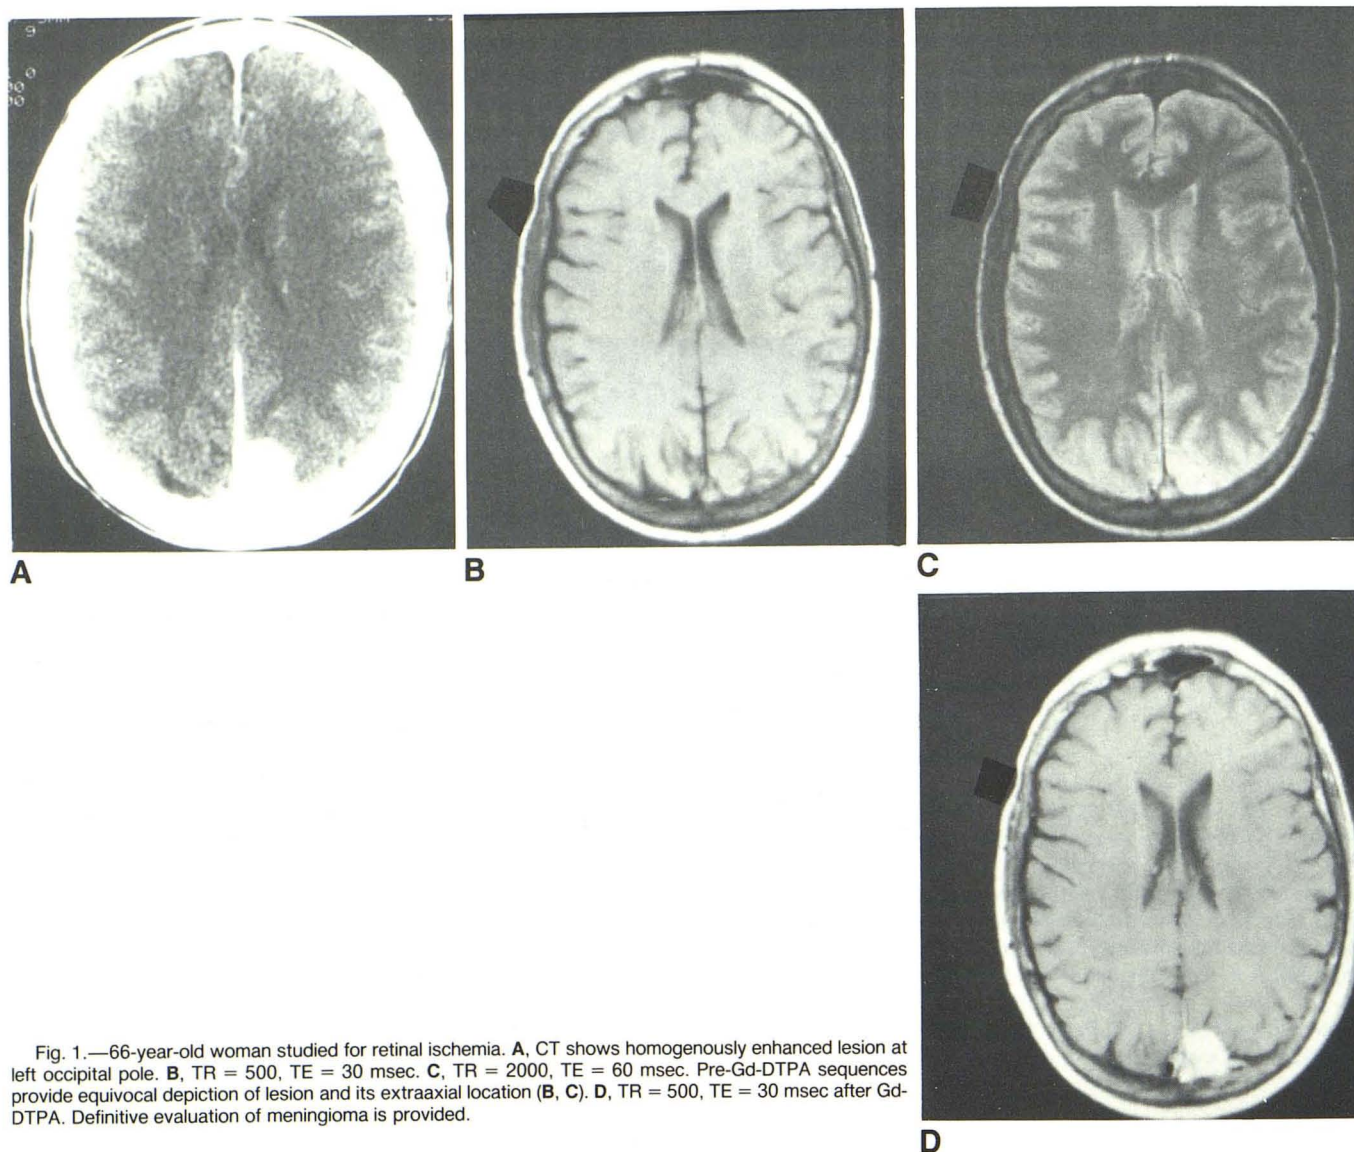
66-year-old woman studied for retinal ischemia. A, CT shows homogeneously enhanced lesion at left occipital pole. B, TR = 500, TE = 30 msec. C, TR = 2000, TE = 60 msec. Pre-Gd-DTPA sequences provide equivocal depiction of lesion and its extraaxial location (B, C). D, TR = 500, TE = 30 msec after Gd-DTPA. Definitive evaluation of meningioma is provided.
